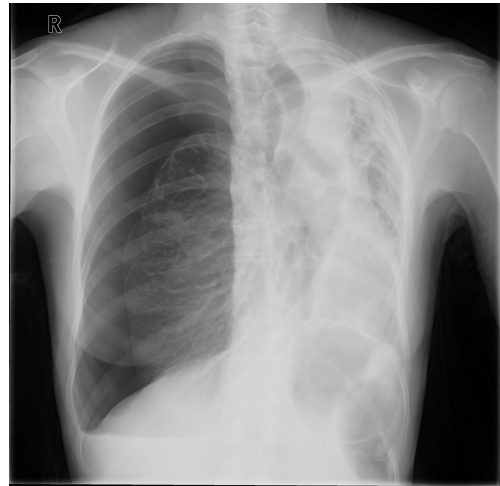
Chest radiograph on admission showing right-sided pneumothorax with severe volume loss and fibrotic changes in the left lung consistent with destroyed lung due to previous pulmonary tuberculosis.
